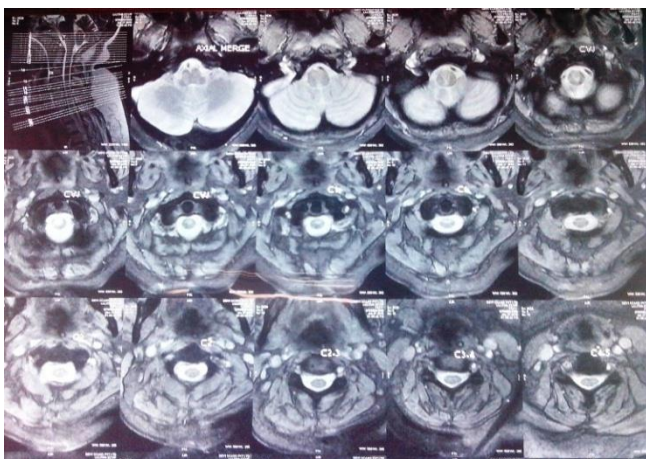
MRI Cervical Spinal cord
